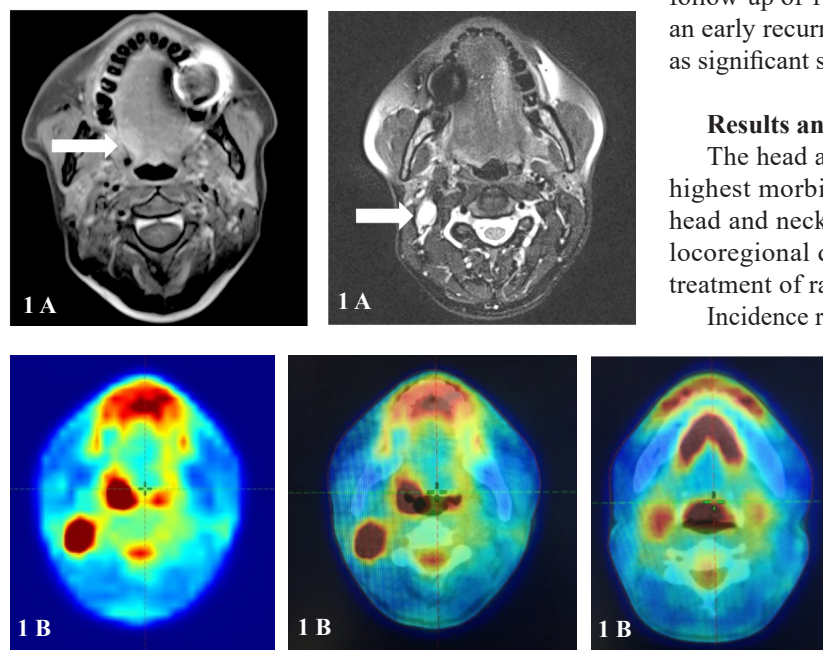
Magnetic resonance imaging (A) and PET-CT (B). A primary tumour diffusely invading into the right side of base of tongue with extension to lingual surface of epiglottis on the PET CT. The cervical lymph node near the internal jugular vein and common carotid artery was uniformly enlarged.
